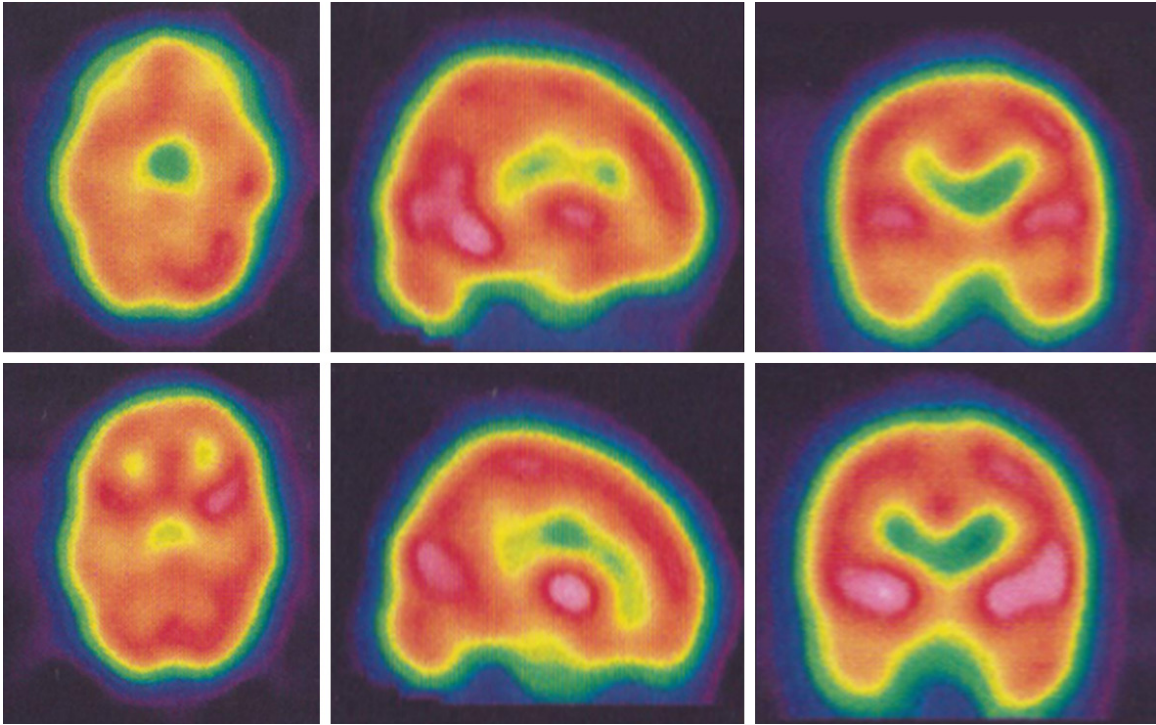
Pre-treatment (upper rows) and post-treatment (lower rows) SPECT images of a 12-year-old CP patient. There is a mild diffuse cortical and subcortical hypoperfusion on pretreatment ^{99m}Tc -ECD brain perfusion SPECT, which is normalized after O₂ therapy. The left columns indicate transvers ^{99m}Tc -ECD SPECT images; the middle columns indicate sagittal ^{99m}Tc -ECD SPECT images; and the right columns indicate coronal ^{99m}Tc -ECD SPECT images.
